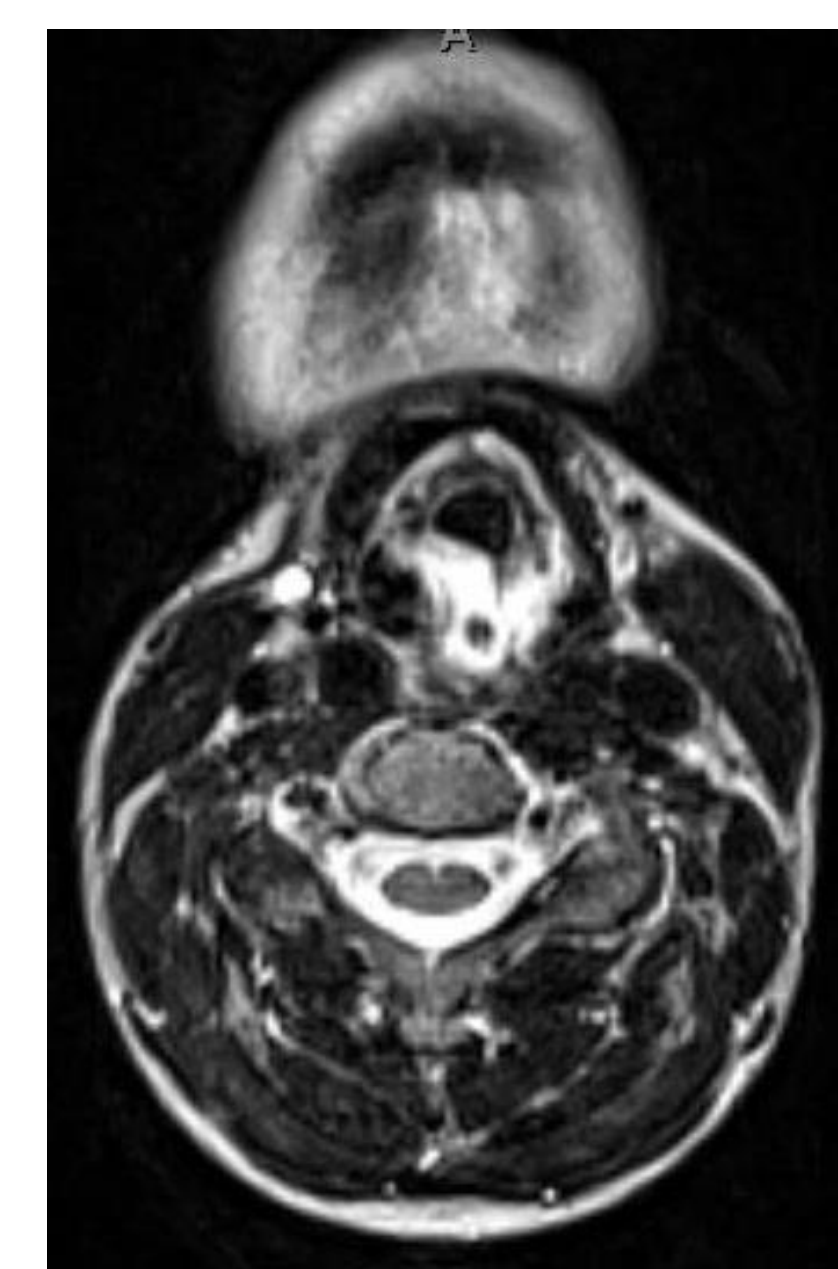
An axial CT image demonstrating thickening of the right hypopharyngeal soft tissues.
